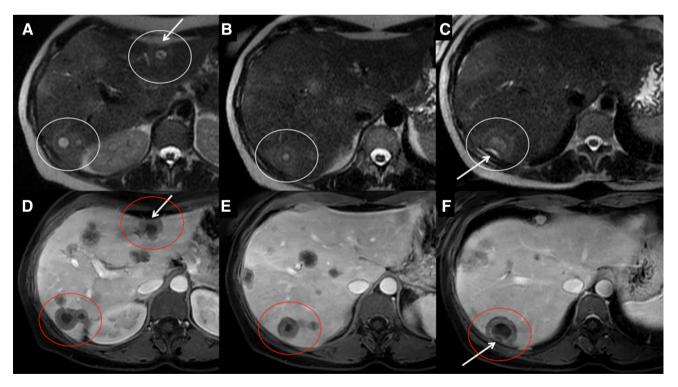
MRI of a 43-year-old female with HEH. HEH nodules show a three-layered target appearance (white circles) on T2-w images (A-C). After contrast medium administration, these
